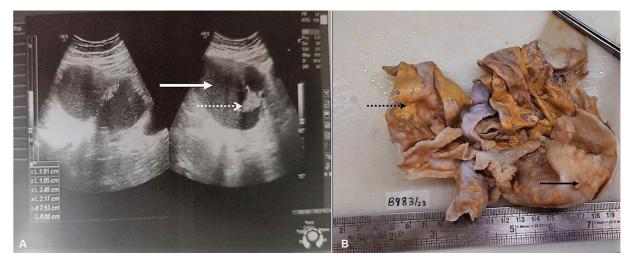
(A) Ultrasound showing a cystic lesion (line arrow) with minor solid component and internal septations (dotted arrow). (B) Cut section of the ovarian cyst showing papillary excrescences (line arrow) and large areas of yellowish discoloration on the cyst wall (dotted arrow).
